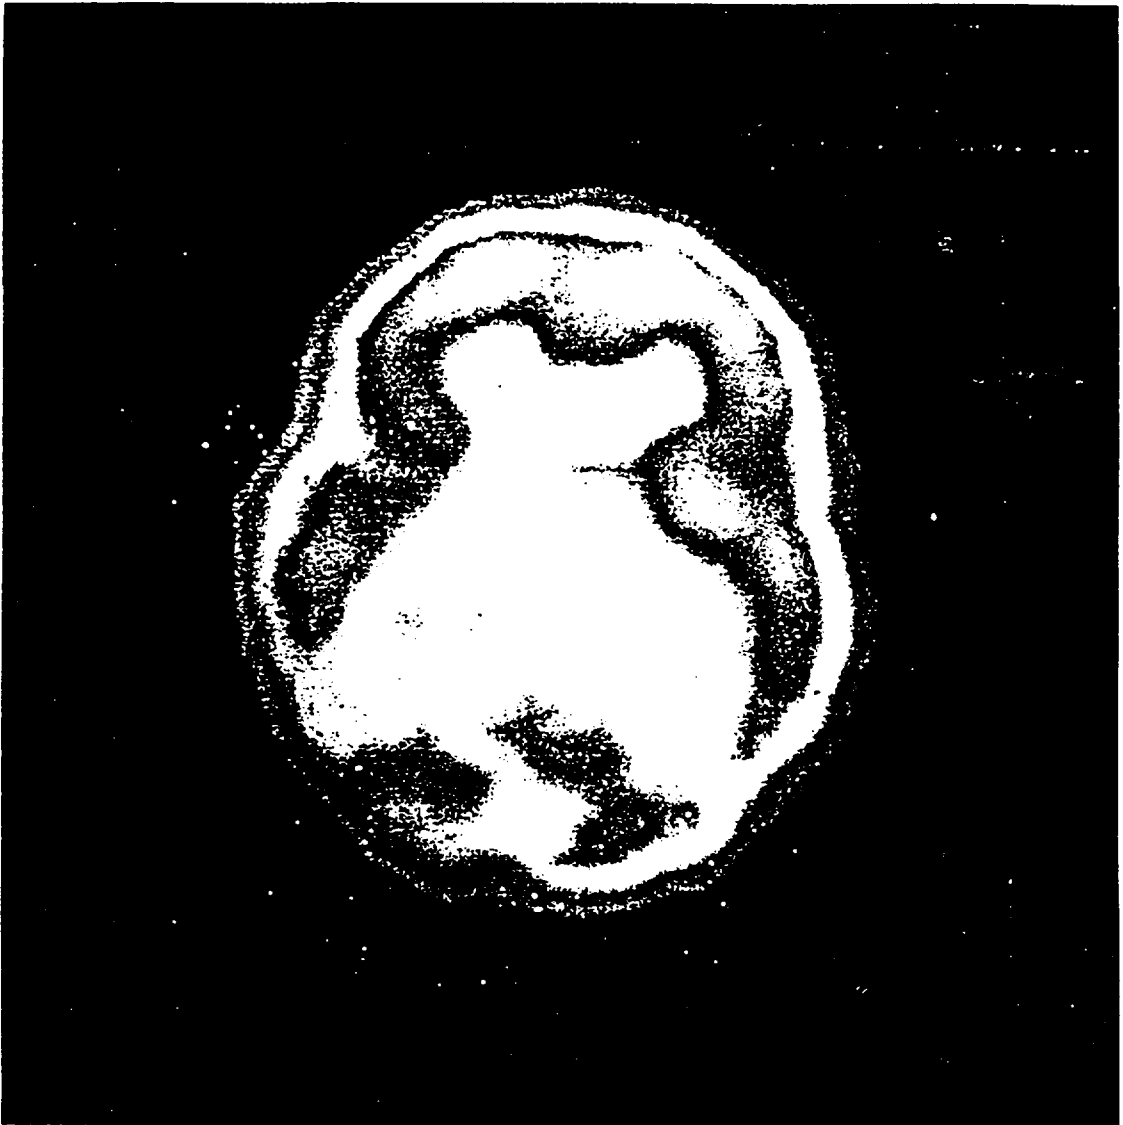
^{99m}Tc HMPAO SPECT STUDY (Transaxial slice) in interictal phase showing decreased perfusion in the right parieto-occipital region.
